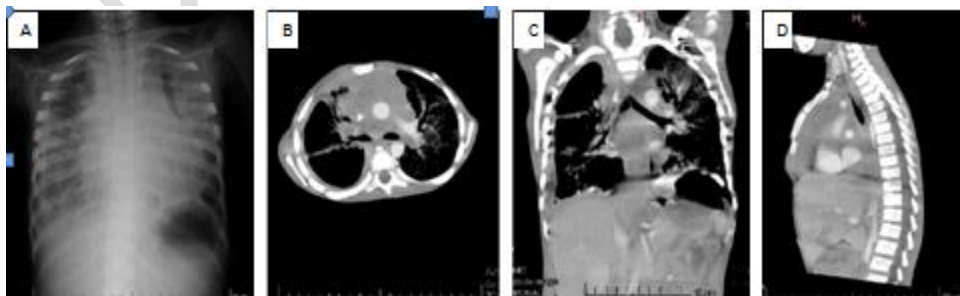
Frontal chest radiograph (A) showing bilateral widening of mediastinum. Axial (B), Coronal (C) and Sagittal (D) CT images demonstrate bilateral large heterogenous mediastinal mass occupying most of the anterior mediastinum.
